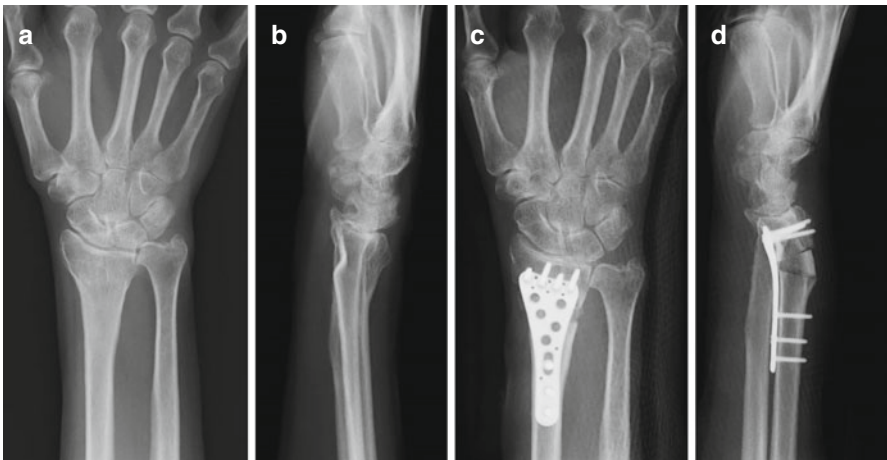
Preoperative AP view (a) and lateral view (b) as well as postoperative AP view (c) and lateral view (d) on a plain radiograph. In this case a block bone graft harvested from the ilium was inserted into the bone defect
